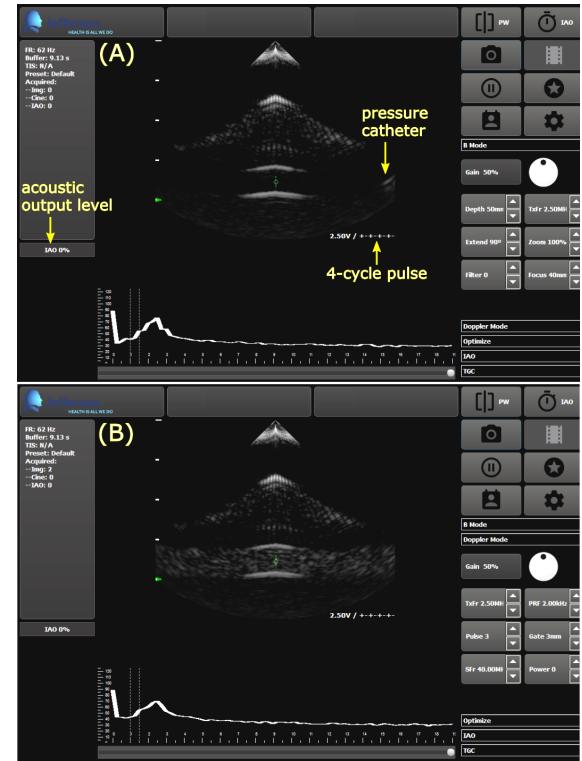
Customized interactive interface on the SonixTablet ultrasound scanner showing the *in vitro* 6 mm vessel (A) without and (B) with ultrasound contrast (Definity in this example). Transmitting parameters are manipulated on the right panel. The pressure catheter is visible within the vessel, but away from the sample gate such that it does not interfere with the flow of the contrast agent.
